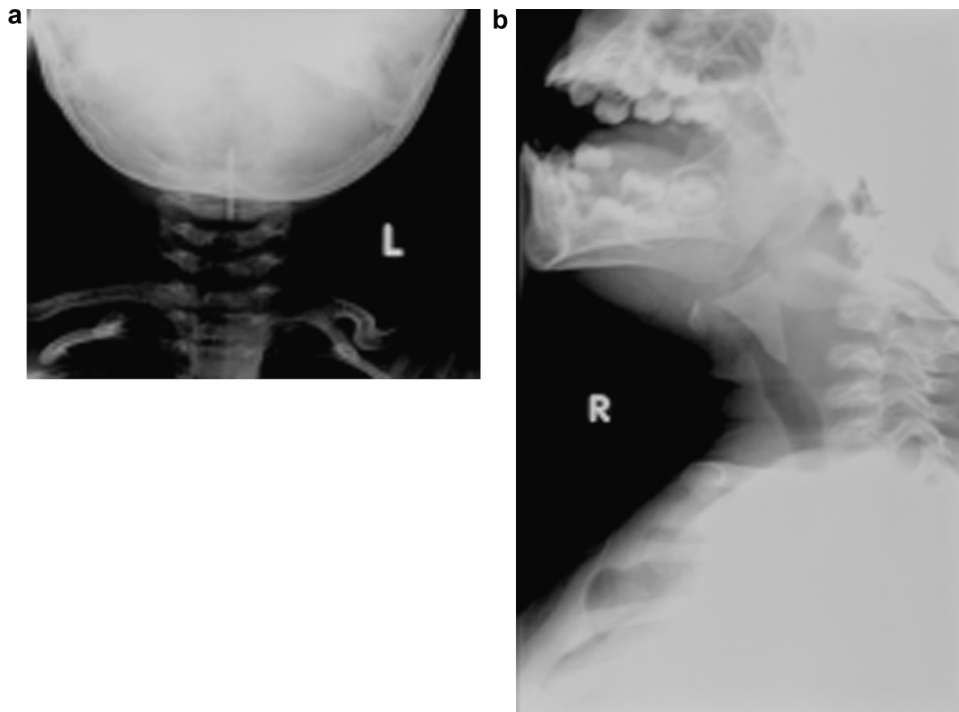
(a) Anteroposterior neck radiograph demonstrating a radiopaque foreign body in the glottis and (b) lateral neck radiograph demonstrating a radiopaque foreign body in the glottis.
